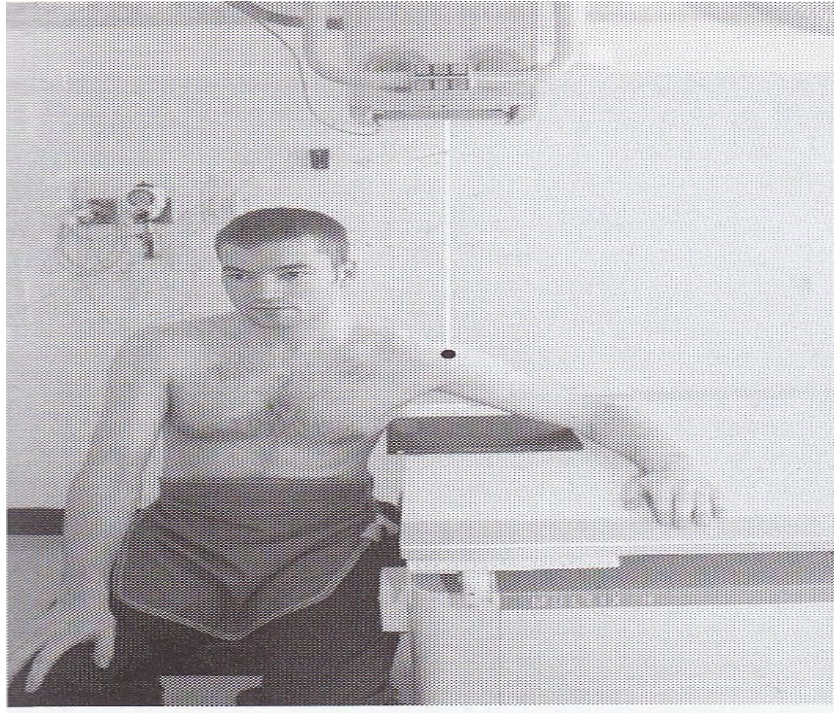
A photograph showing the position of a patient taking a superior-inferior axial projection where the arm is approximately abducted at 45 degrees. Notice the superior direction of the x-ray beam (white line) signifying the term of this projection where the cassette is placed inferior to the shoulder joint (Whitley et al., 2005).
